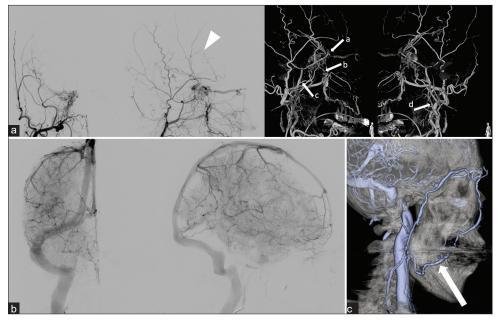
Digital subtraction angiography (DSA) and 3D-DSA (a). On external carotid angiography, the patient was diagnosed as cavernous sinus dural arteriovenous fistula, and the arrow head shows pseudo phlebitic pattern. The arrows show feeders; a: Middle meningeal artery, b: Artery of foramen rotundum, c: Accessory meningeal artery, and d: Ascending pharyngeal artery. DSA (b). On internal carotid angiography, inferior petrosal sinus was not visualized on venous phase. (c) CT venography. Inferior petrosal vein was not detected, and the arrow shows that facial vein was well visualized.
